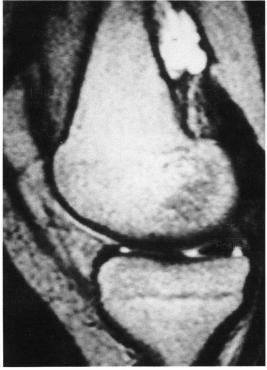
T2-weighted sagittal MR image also reveals a lobulated, bright signal lesion within the sclerotic cortex.
